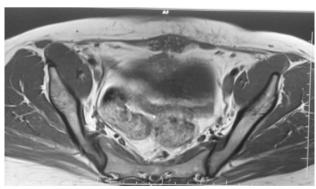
Axial T1W MR image redemonstrating a fusiform isointense heterogenous mass with hyperintense foci in anterior abdominal wall which has posterior extension in pelvic cavity, infiltrating dome of urinary bladder.
